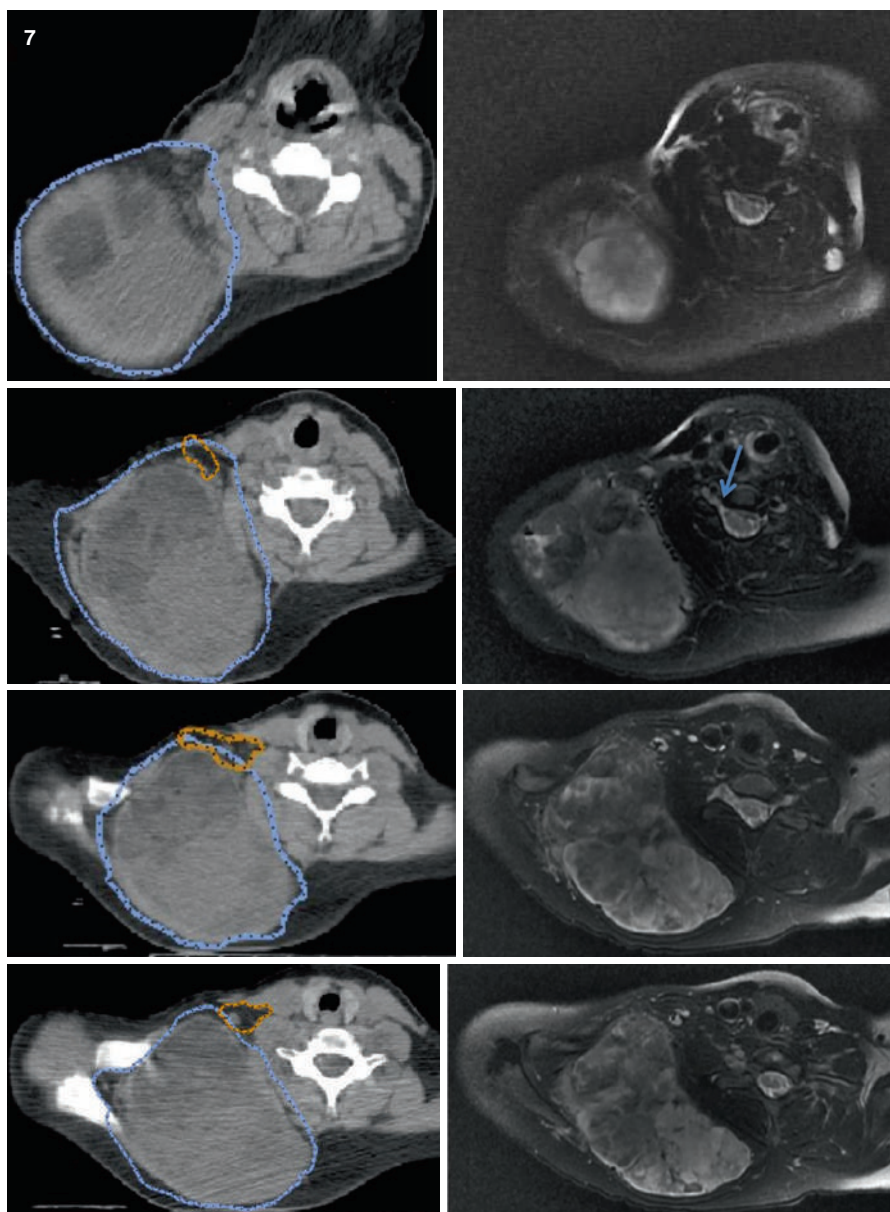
Preoperative MRI and PET of the right posterior shoulder/upper back of an 11-year-old with high-grade undifferentiated soft tissue sarcoma. The patient received neoadjuvant chemoradiotherapy followed by surgical resection. Surgical margins were negative, and a postoperative boost was not recommended
